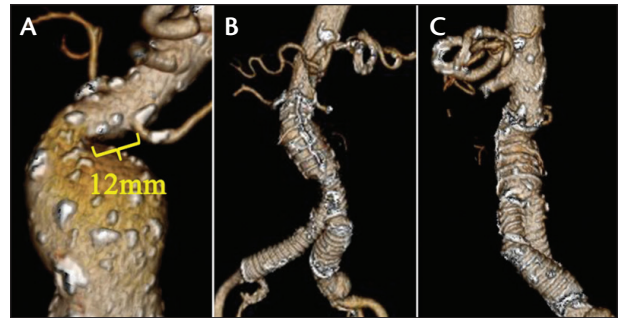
Patient treated at the University of Florida with a highly angulated neck (88°) at implantation. The infrarenal neck measured 16 mm along the centerline and 12 mm along the lesser curve (A). Complete sac shrinkage around the graft was noted on the 4-year follow-up CT. Panels B and C demonstrate straightening of the infrarenal neck along with the graft at last follow-up.
